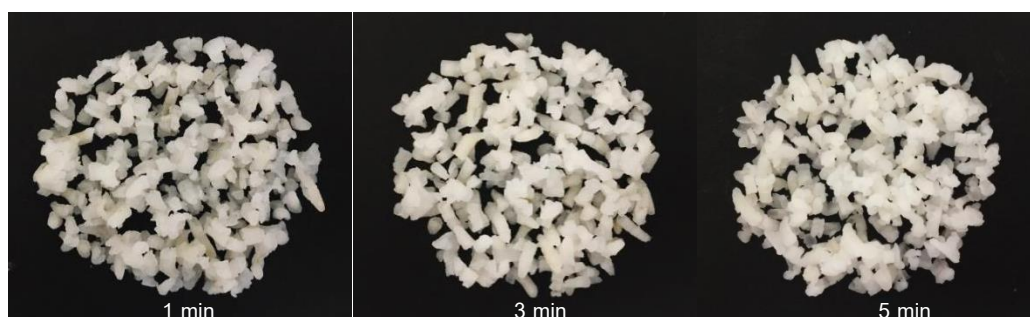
Appearance of cooked rice from ultrasonic treatment
